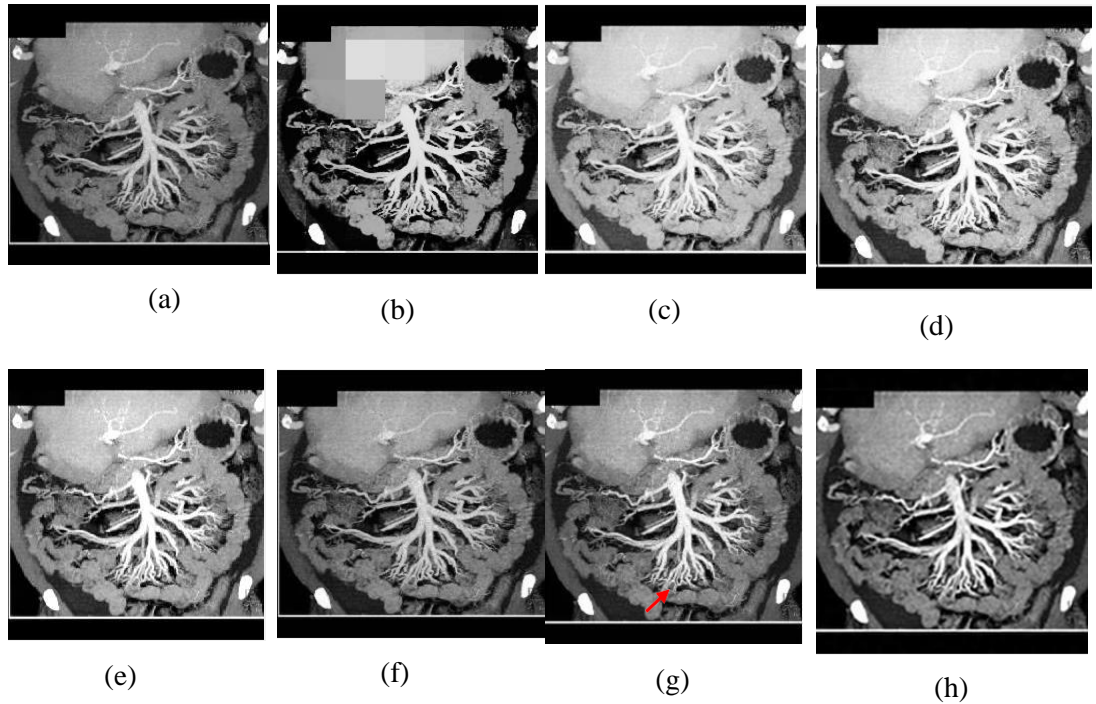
Experiment outcomes of the 'CT-4' Image (a) Original image, (b) S-curve, (c) AGC-DWT, (d) AGC-WHD, (e) GAGC-DWT, (f) EBCHE, (g) TCHE-DWT, (h) Proposed scheme
